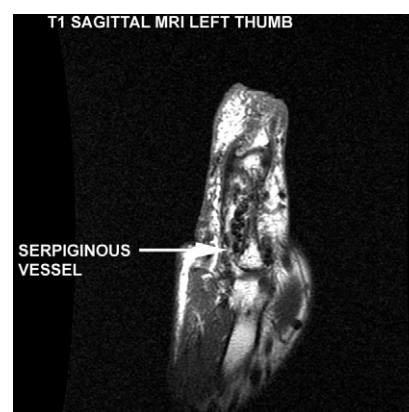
MRI confirmed a large vascular malformation of the left thumb by demonstrating large serpiginous vessels in both the soft tissues and the proximal and distal phalanges. The largest intraosseous vessel corresponds with the lucency shown on the plain film (figure 2).
